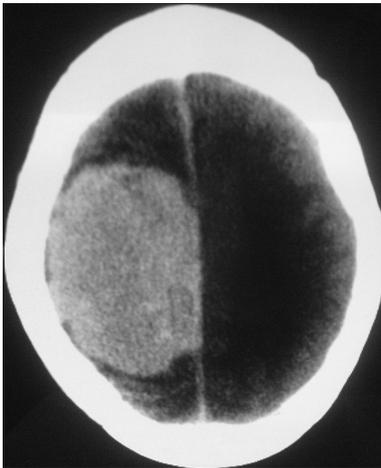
CT Brain showing meningioma
